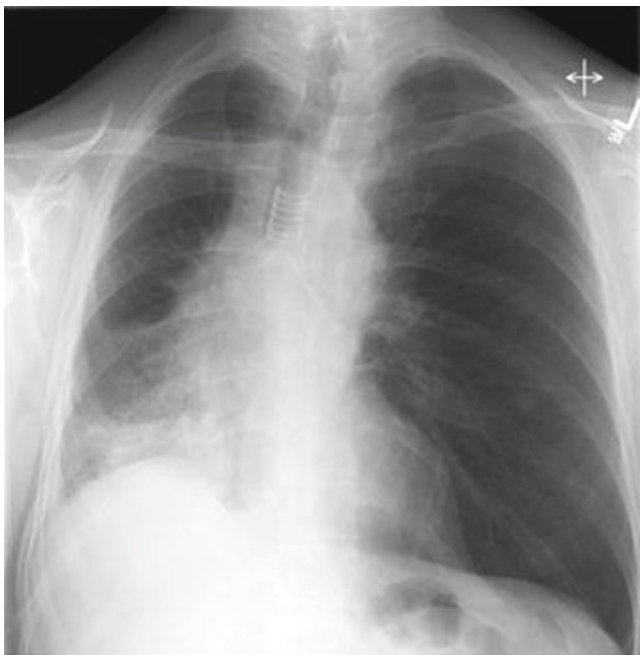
Chest X-ray after implantation of a Dynamic Y-stent
